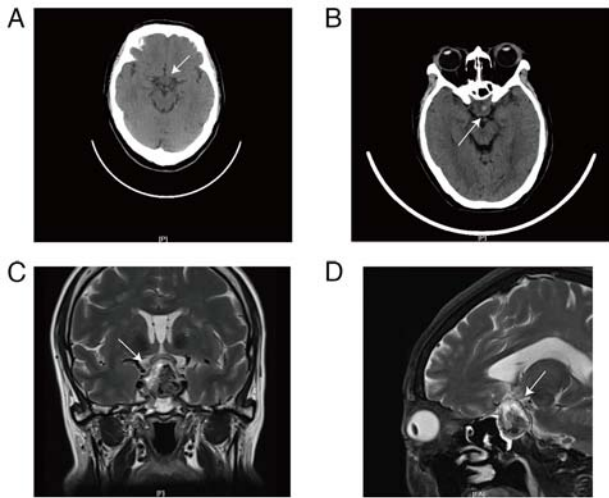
Imageological examination. (A) No obvious abnormalities were detected in the pituitary gland (arrow) on pre-operative positron emission tomography-CT scans. (B) Local density increase in the sella turcica and suprasellar regions (arrow) was observed in the transverse section on CT on POD4. (C and D) Contrast-enhanced sellar MRI showed a 2.4x1.7x2.6 cm-sized mixed signal (arrow) expanding from the sellar fossa and suprasellar region and compressing the optic chiasm in the (C) coronal and (D) sagittal section on POD4. POD4, postoperative day 4.
